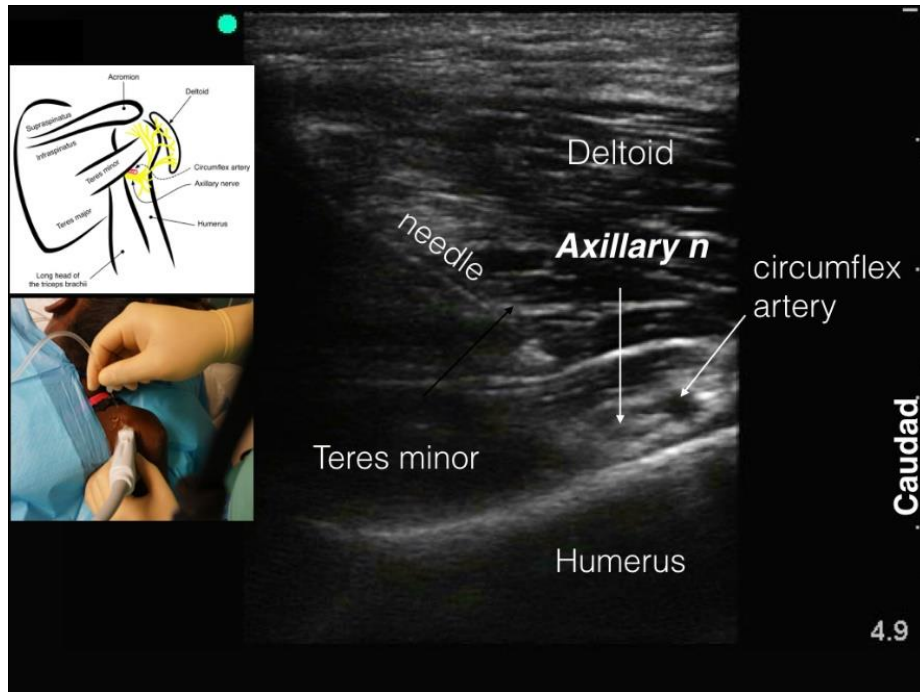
Ultrasound guided axillary nerve block [24]
